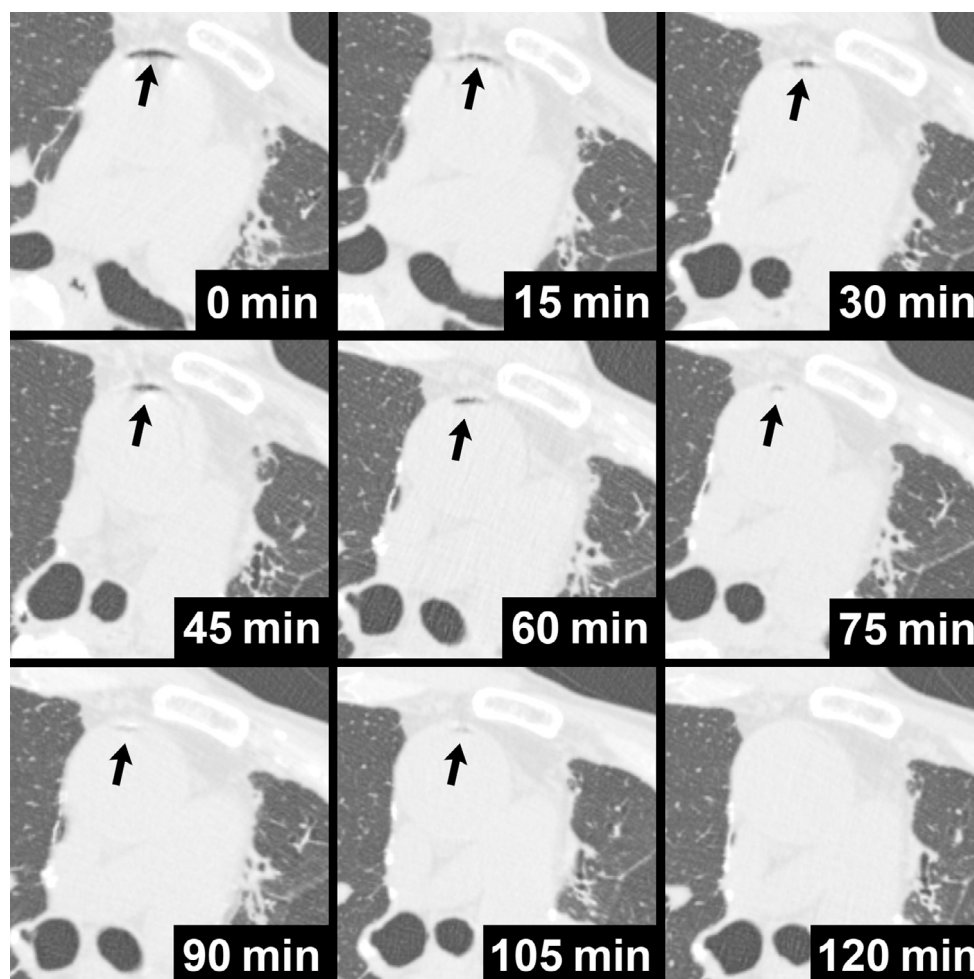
Air changes in the ascending aorta up to 2 h after biopsy. Computed tomography (CT) was intermittently performed from the time of air emboli identification, revealing a gradual reduction in the remaining ascending aortic air, which disappeared entirely after 2 hours (arrows).
